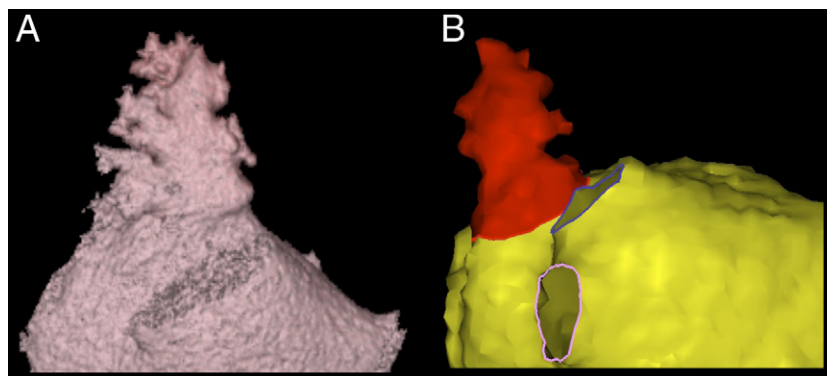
CT and MRI Scans of a Cactus LAA Morphology
